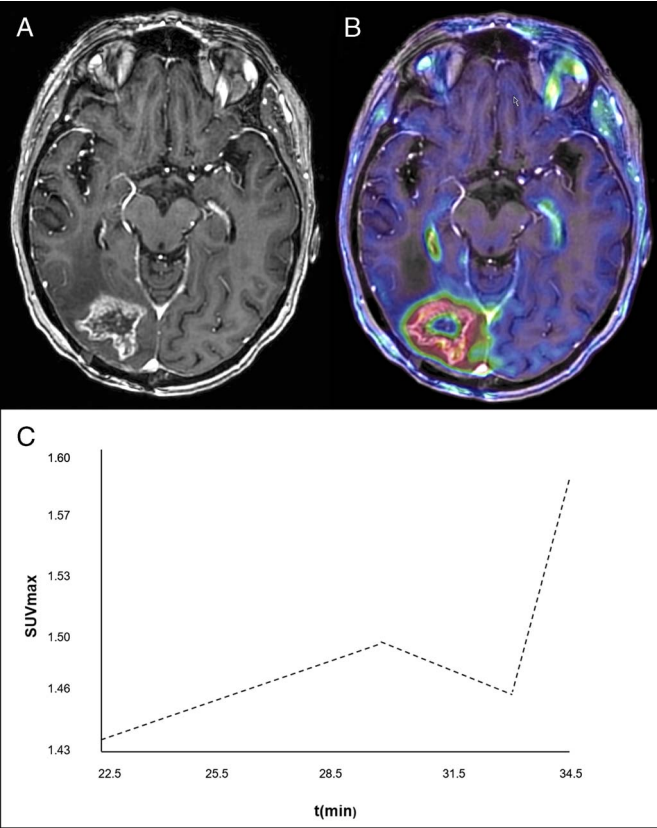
A and B, MRI and ¹⁸F-FET PET/MRI images of a patient with pseudoproggression. C, Dynamic ¹⁸F-FET “wash-in” pattern of the same patient.
